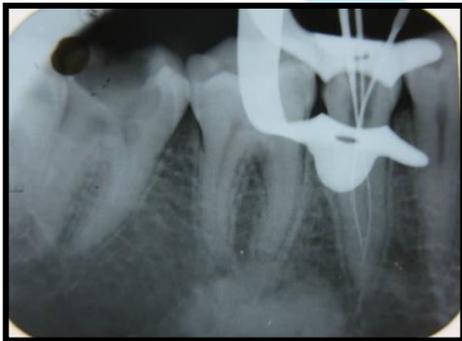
Working length determination radiograph
